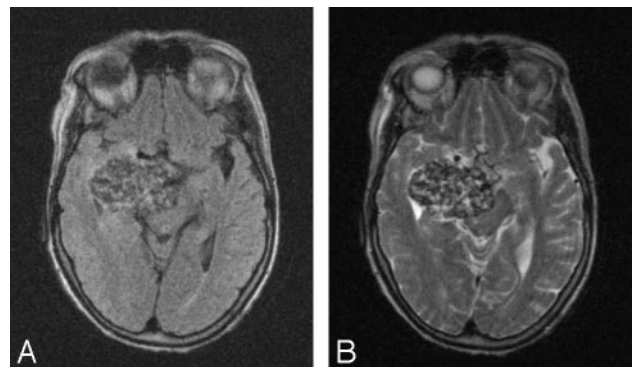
Fibrous meningioma (A) FLAIR image (relative intensity of tumor, 0.72). B, T2-weighted image (relative intensity, 0.83). Surgical bleeding, grade 1.5 on VAS and blood loss, 250 mL; hardness 7.5 on VAS; collagen content, 3; progesterone receptor expression, 0; microvessel density, 81 microvessels/mm². Time to maximum enhancement in dynamic imaging was 90 seconds from the time point when contrast agent arrived in the veins.
